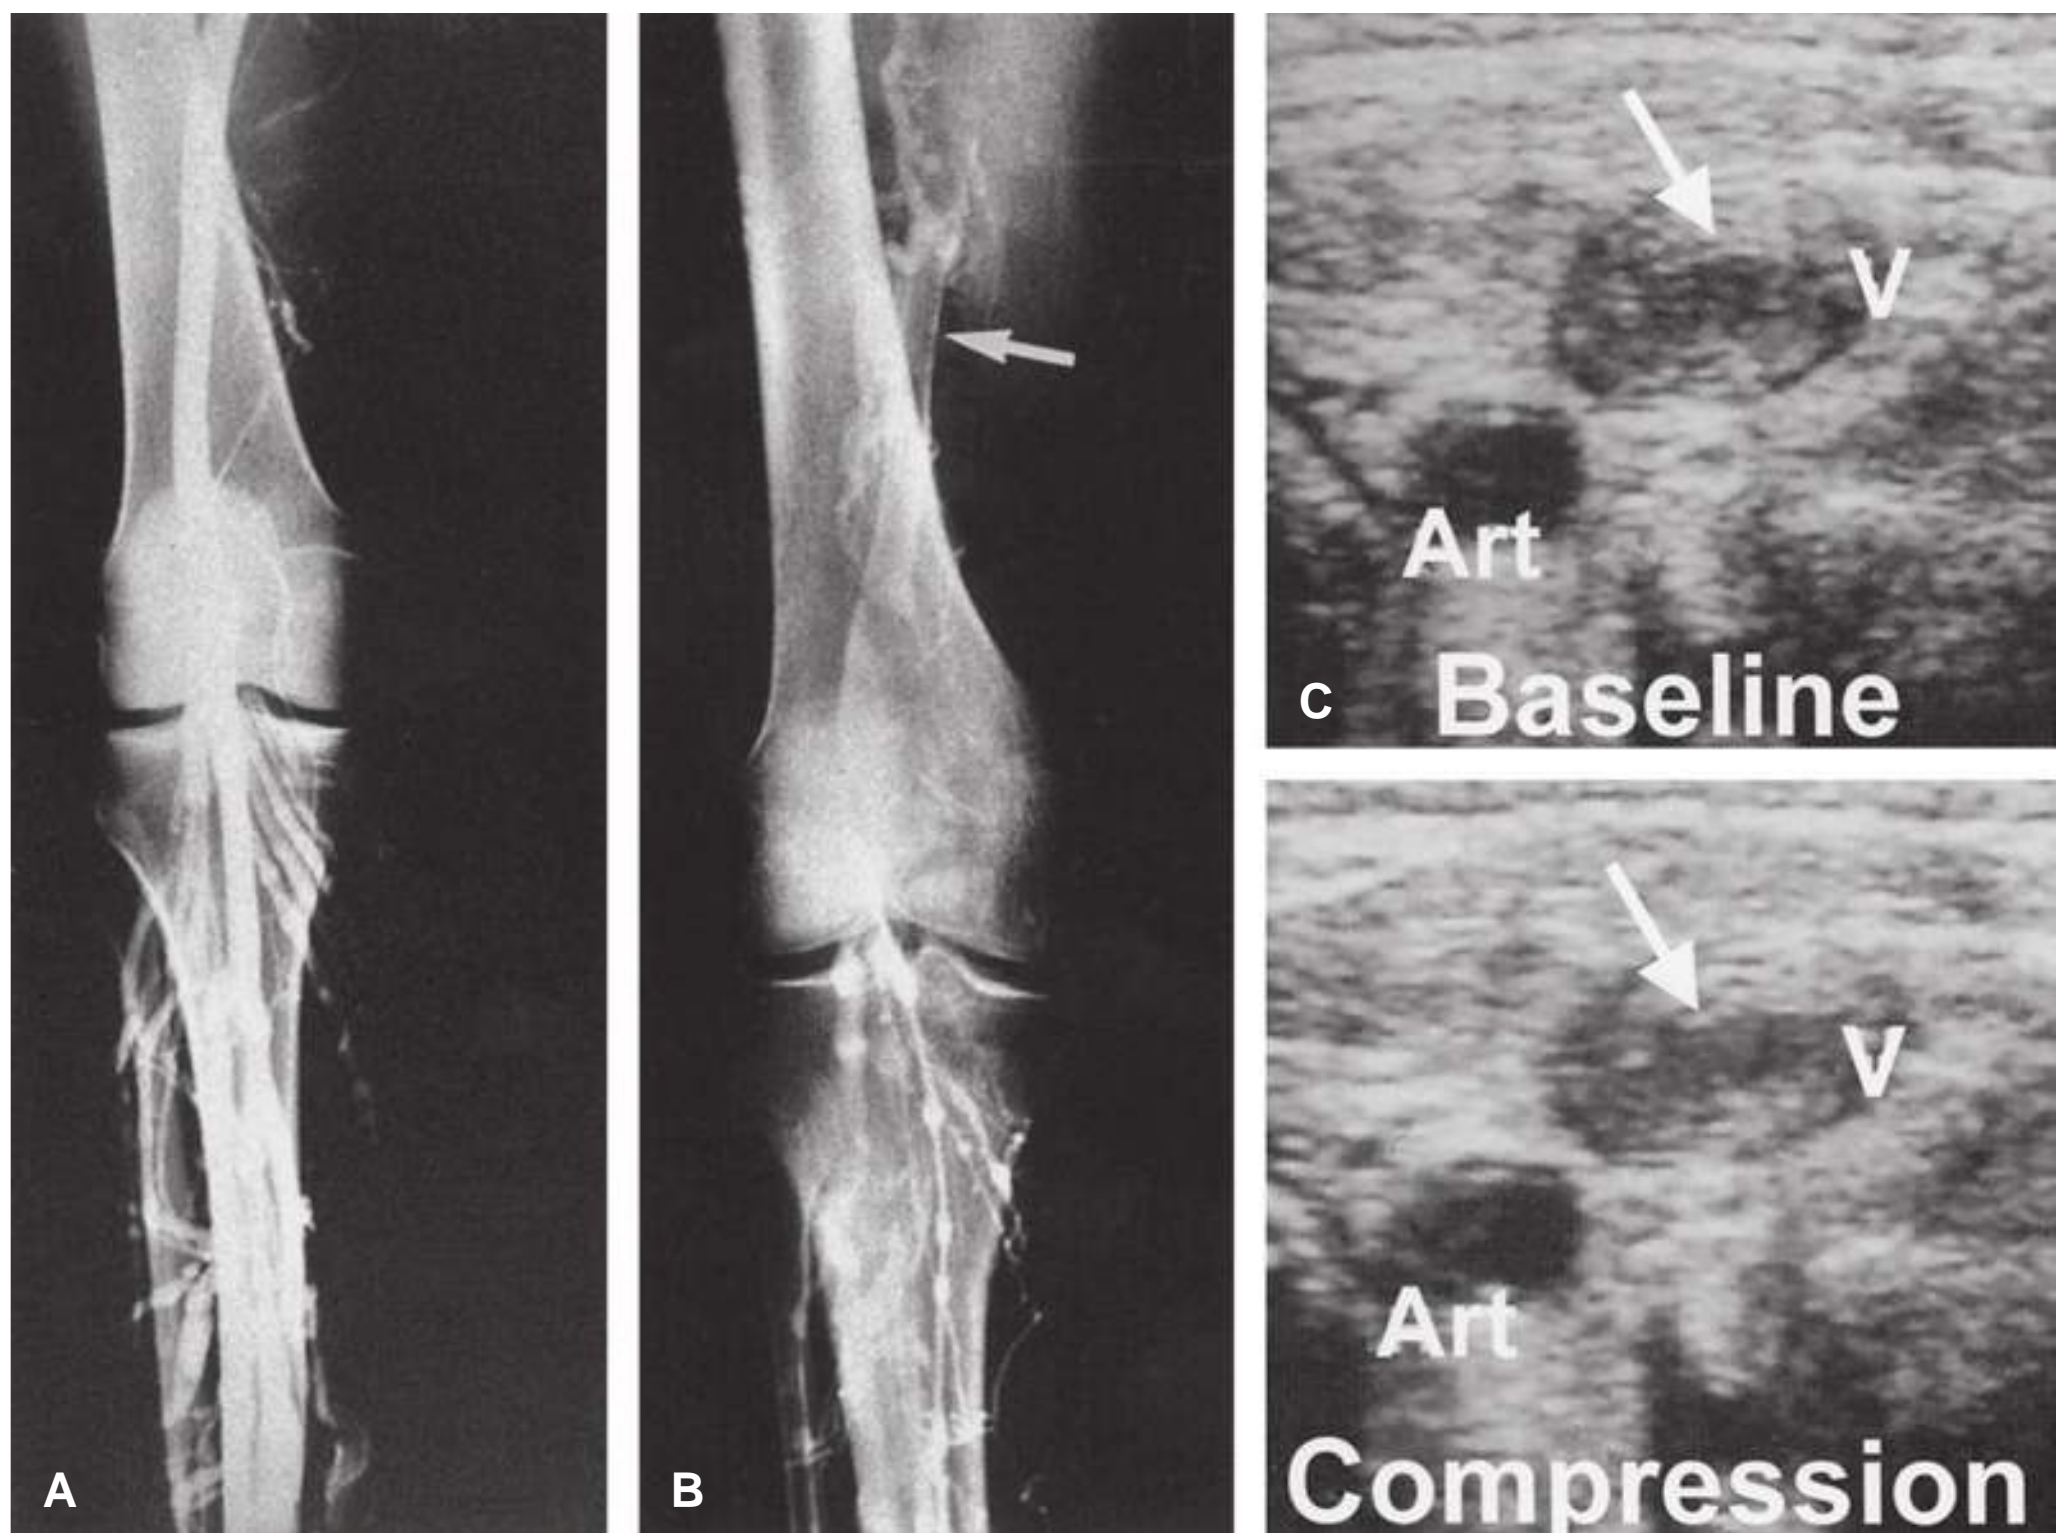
Diagnostic imaging of deep venous thrombosis. A. Normal venogram. Contrast material was injected into a foot vein and fills the leg veins in this radiograph. B. Venogram demonstrating extensive thrombosis of the deep calf veins, popliteal vein, and femoral vein. Arrow indicates a filling defect in the femoral vein due to the presence of thrombus. The deep calf veins are filled with thrombus and cannot be visualized. C. Ultrasound indicating deep venous thrombosis. The thrombus appears as an echogenic area (arrow) within the femoral vein (V). A healthy vein would be easily compressible by the ultrasound transducer. This vein, however, has the same diameter at baseline (top panel) and after compression (bottom panel), confirming the presence of thrombus within it. Art, artery.
